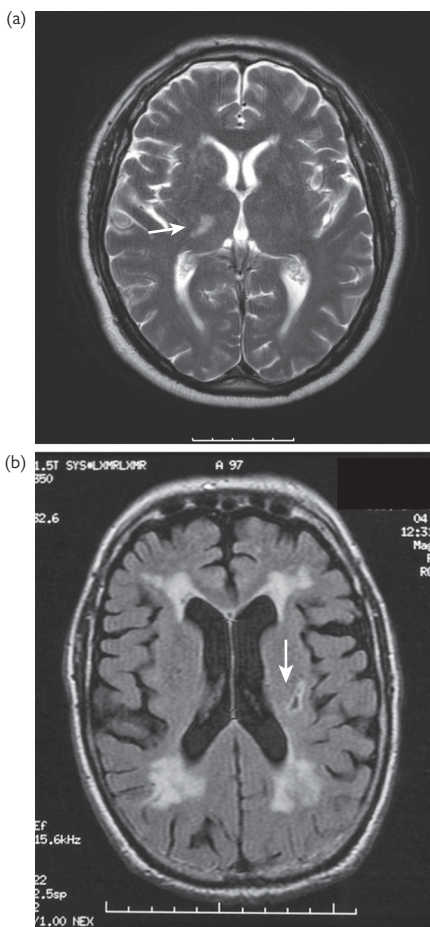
MRI scans from patients with cerebral small-vessel disease. Both have presented with lacunar stroke. (a) A single larger lacunar infarct (arrowed) and no leukoaraiosis is seen; (b) image shows the combination of lacunar infarcts (arrowed) and extensive confluent leukoaraiosis. © Hugh Markus.
